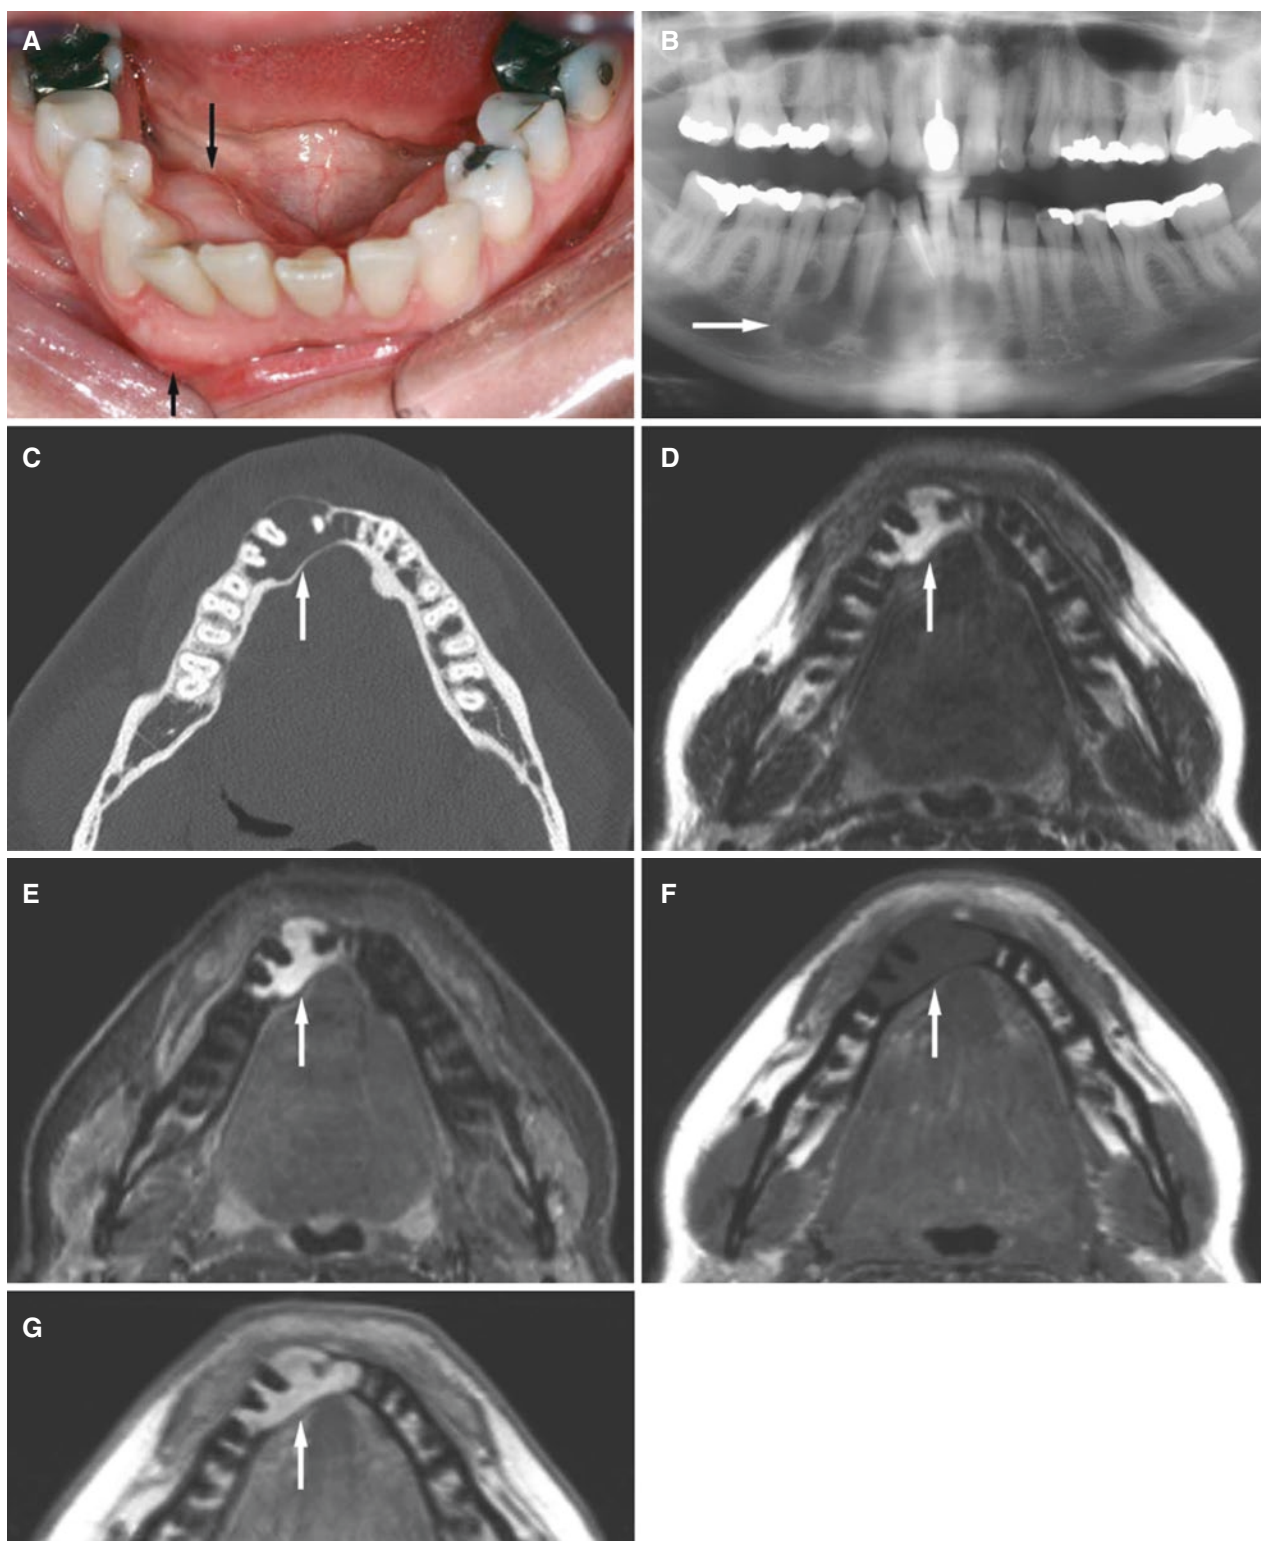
Odontogenic myxoma, mandible; 45-year-old female with painless swelling which the patient did not notice because tumor was “filling out” mandibular torus on the right side. (A) Clinical photograph shows buccal and lingual jaw expansion (arrows). (B) Panoramic view shows scalloped radiolucency without sclerotic outline (arrow). (C) Axial CT image shows expanded but intact buccal and lingual cortical
